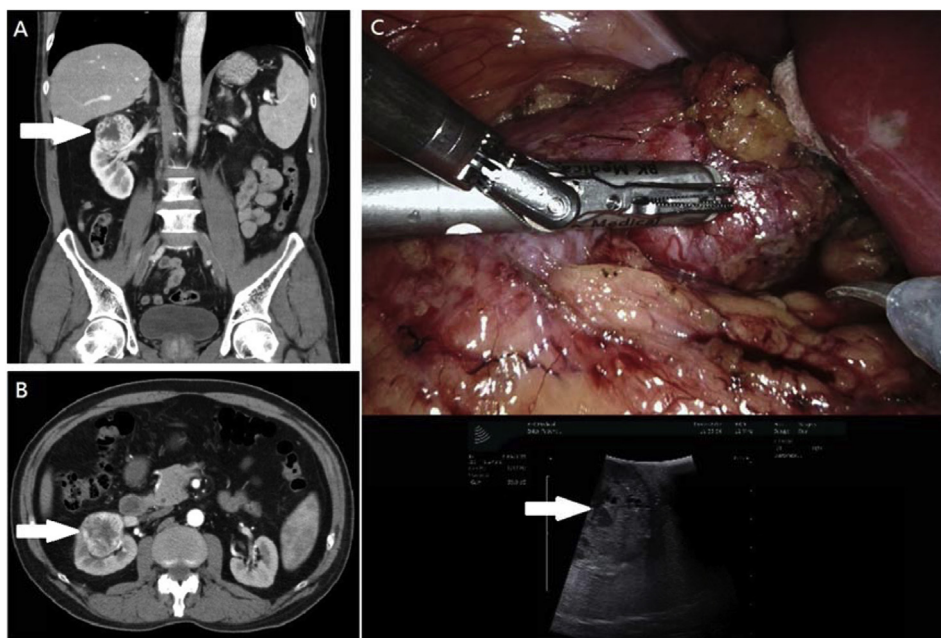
A 69 year-old male patient with a 4.5 cm clear-cell type renal cell carcinoma at upper pole region of right kidney received RAPN without complication. (A) CT coronal view; (B) CT transverse view; (C) drop-in ultrasound with Tilepro multi-input display.
